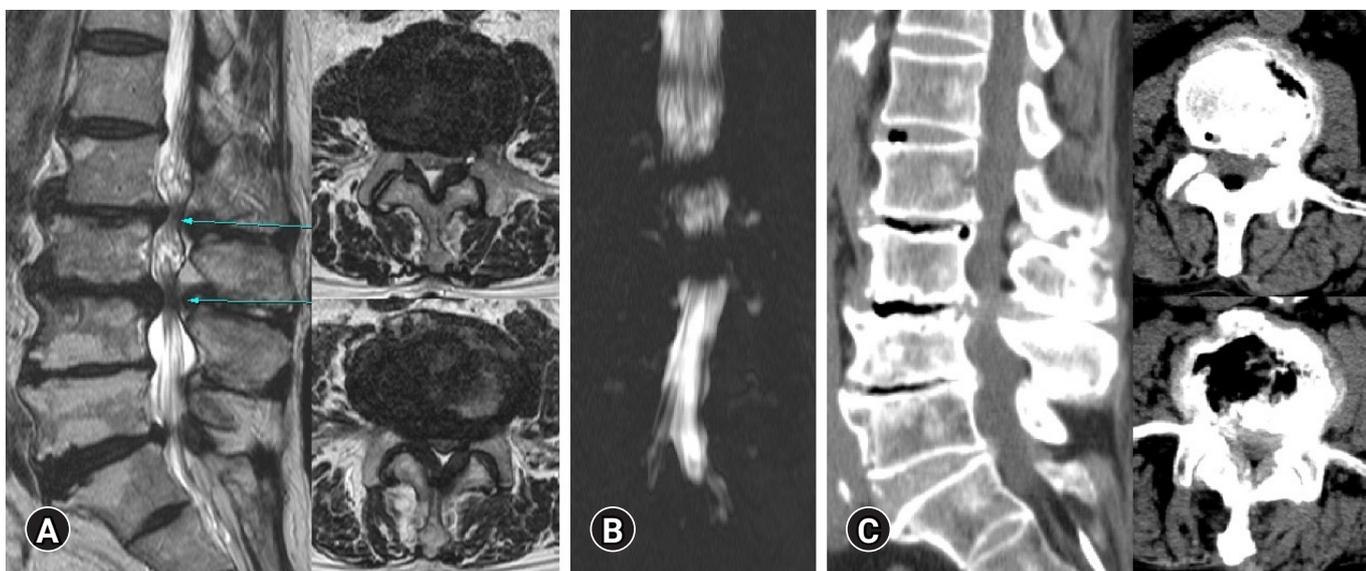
Preoperative images of lumbar spinal stenosis at L2-3, 3-4 level on MRI, MR myelography, and CT. (A) Sagittal and axial images on T2 weighted MRI. (B) An image on MR myelography. (C) Sagittal and axial images on CT.
